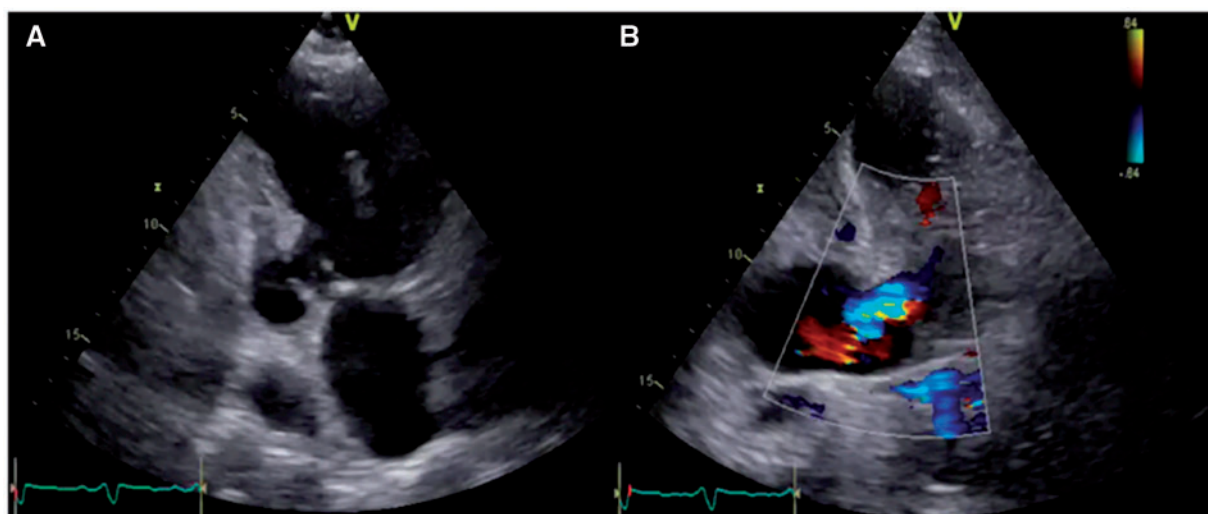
(A) Apical two-chamber view showing (A2C) a pseudoaneurysm at the basal inferior wall of the left ventricle (LV) with a communication neck of 8.5 mm. (B) Apical two-chamber view with colour Doppler imaging showing blood circulation between the left ventricle and the pseudoaneurysm.
